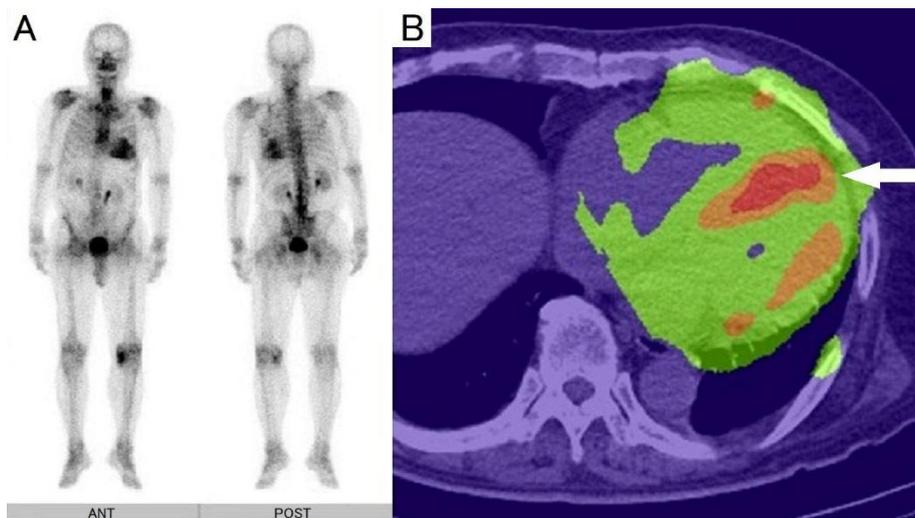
Planar whole-body bone scintigraphy showed myocardial tracer uptake, corresponding to grade 3 (A). SPECT showed particularly strong uptake in the ventricular septum (B) (arrow)
